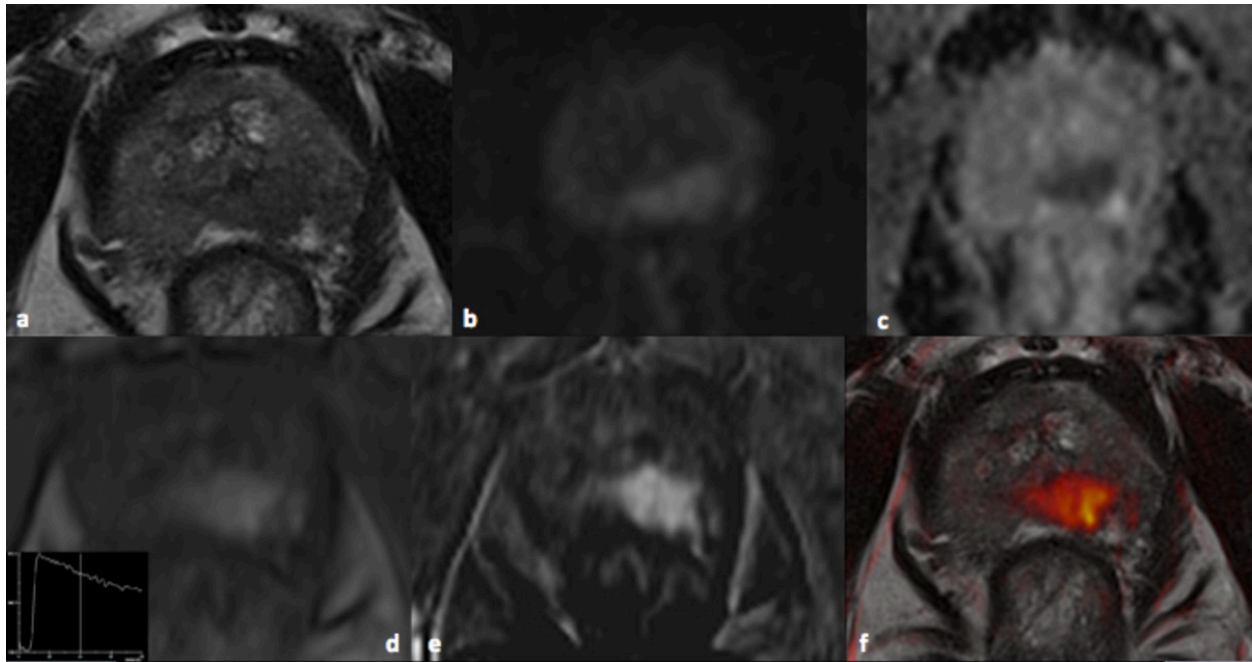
T2W image (a) shows a ill-defined low-signal intensity area in the left posterior peripheral zone causing slight rectoprostatic angle effacement. The lesion has high signal on DWI trace (b) and low signal intensity on the ADC map (c). In early-phase DCE image (d), the lesion shows strong enhancement. Signal intensity curve of the lesion shows a type 3 curve. Subtraction image (d) confirmed high vascularization of the lesion. (e) Fusion image (T2W + DWI trace). TRUS-guided biopsy revealed PCa, Gleason 7 (3+4).
